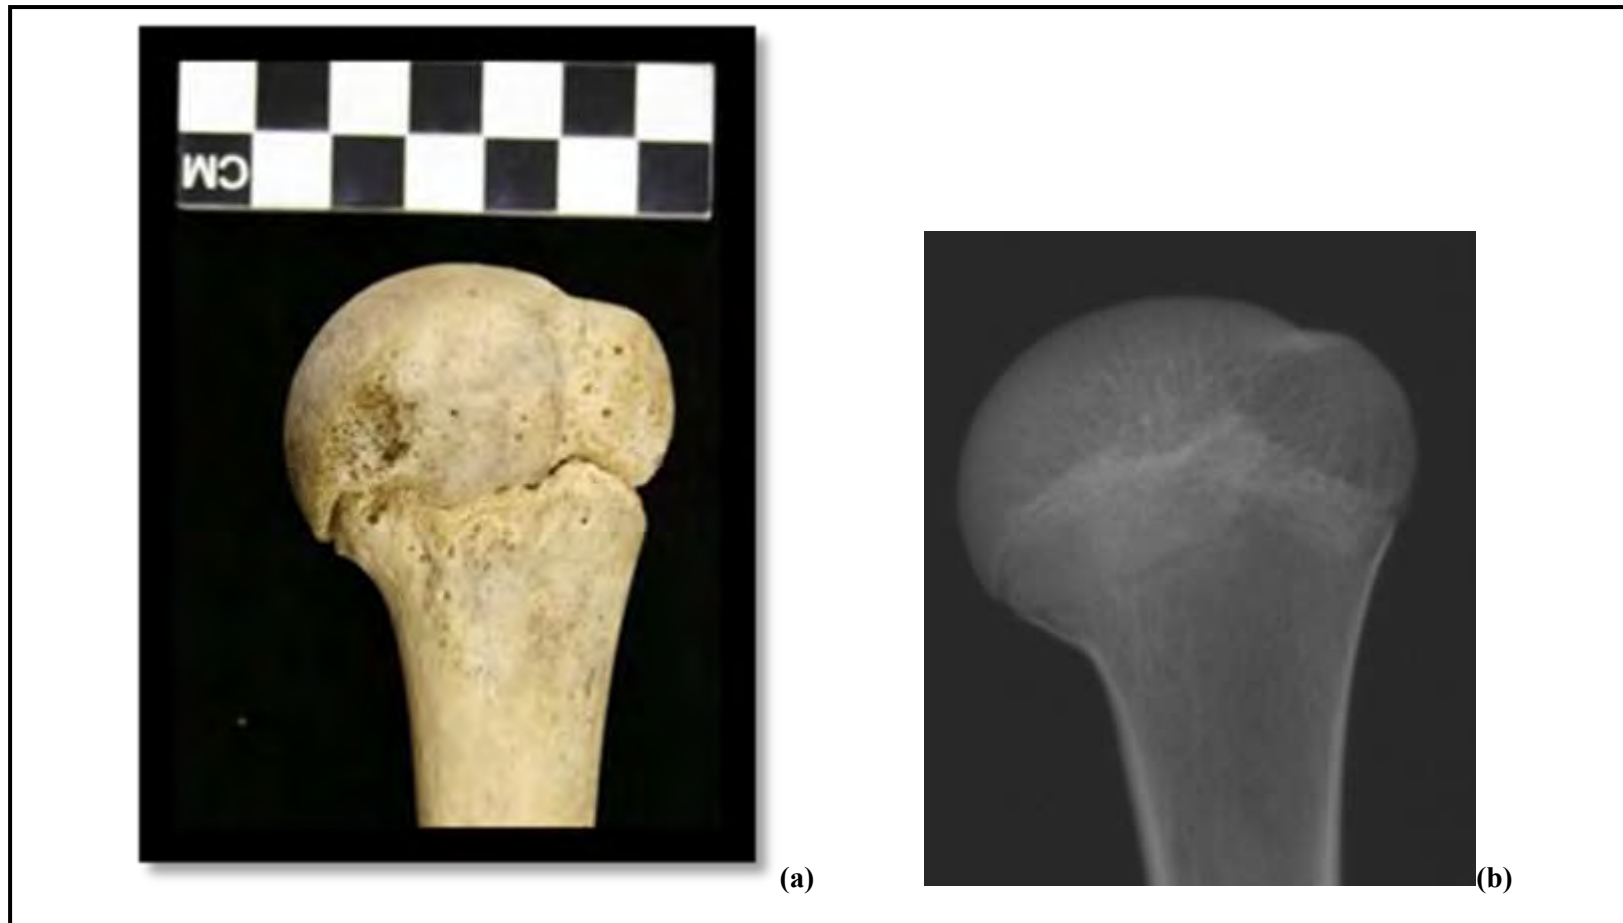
(a) Gross assessment of union at the shoulder in a 16 year old male from the Dart Collection. (b) The Humerus is a radiograph of (a), although it looks as a stage 3 of union in the radiograph, upon analysis it seems that the epiphysis is a separate component and is classified as stage 2 (less than 50% union).
